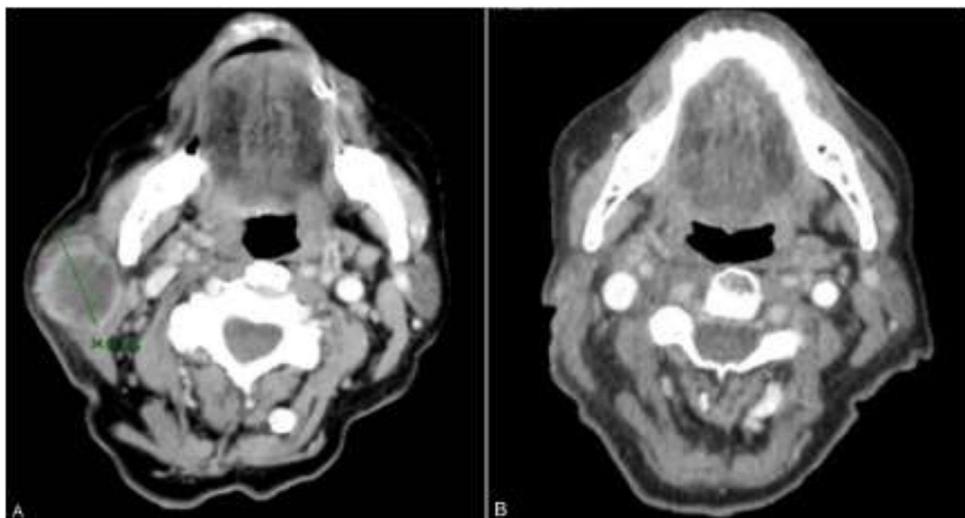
Computed tomography image of the tumor on the right side of the jaw before (A) and after (B) 4 cycles of pembrolizumab.
